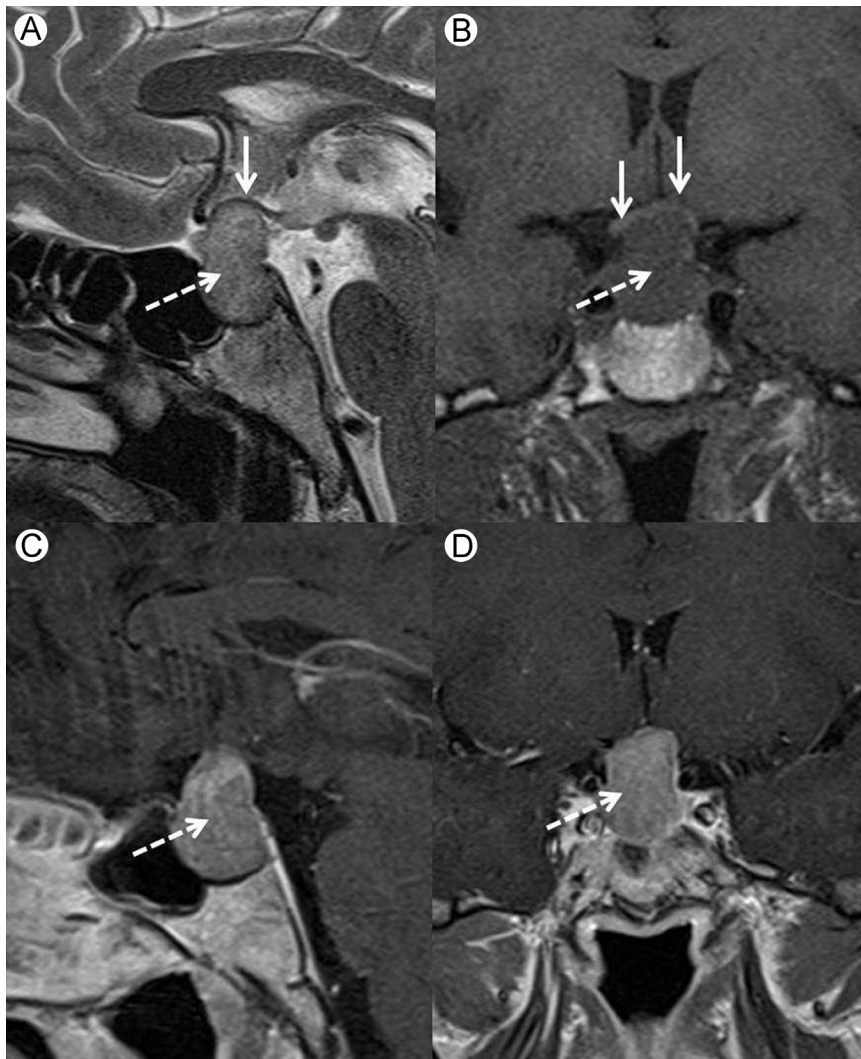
A 32-year-old woman whose optician detected bitemporal hemianopia on routine examination: (A) sagittal T2-weighted; (B) coronal T1-weighted; (C) sagittal; and (D) coronal T1 postcontrast images of the pituitary gland showing a large “snowman-shaped” pituitary mass lesion (dashed arrow), compressing the optic chiasm (solid arrows, A and B), which is fixed posterior to the lesion.
